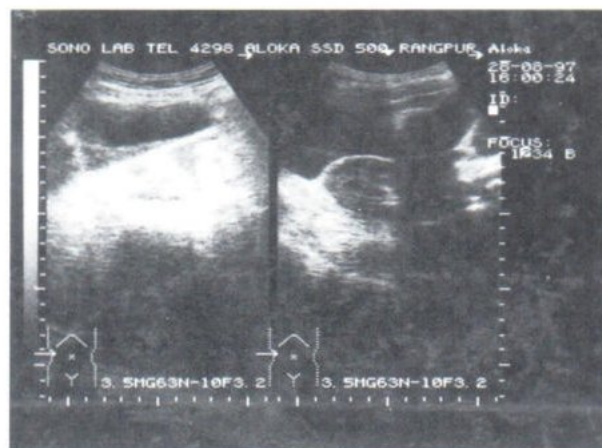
Ectopic gestation : Utility of ultrasonography
